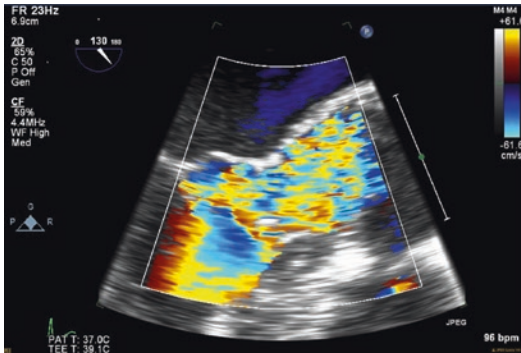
Transesophageal image showing turbulence using color Doppler in the left ventricular outflow tract that begins subvalvular at the level of the subaortic membrane
